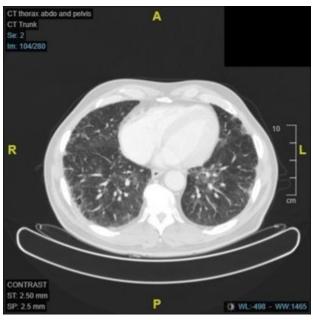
Re-staging CT Thorax after cycle 8
